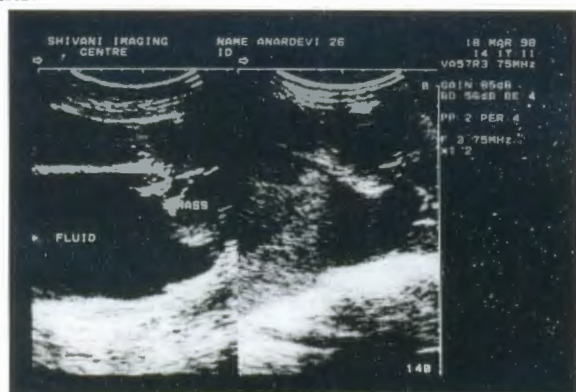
Abdominal sonographic picture showing huge fluid filled cyst with few internal echoes.
